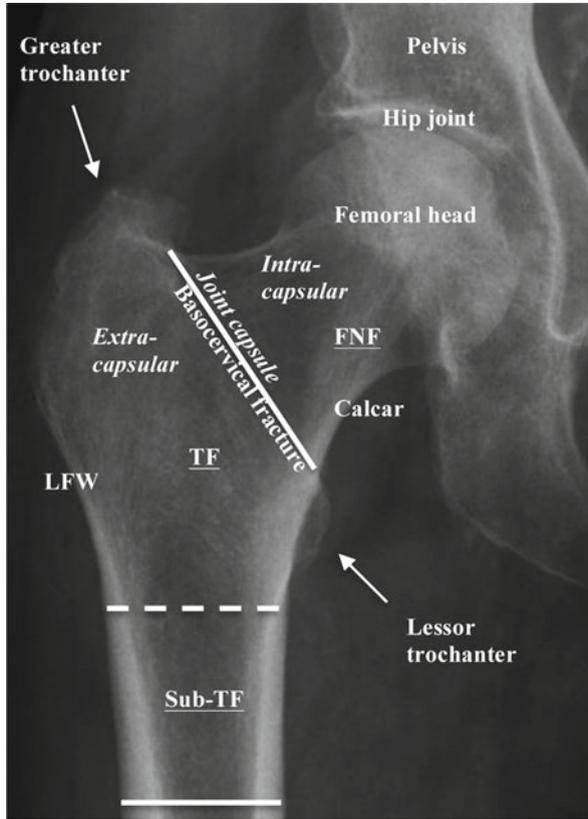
Antero-posterior radiograph of right side proximal femur showing the anatomy and fracture positions. *FNF* femoral neck fracture, *TF* trochanteric fracture, *Sub-TF* sub-trochanteric fracture, *LFW* lateral femoral wall
